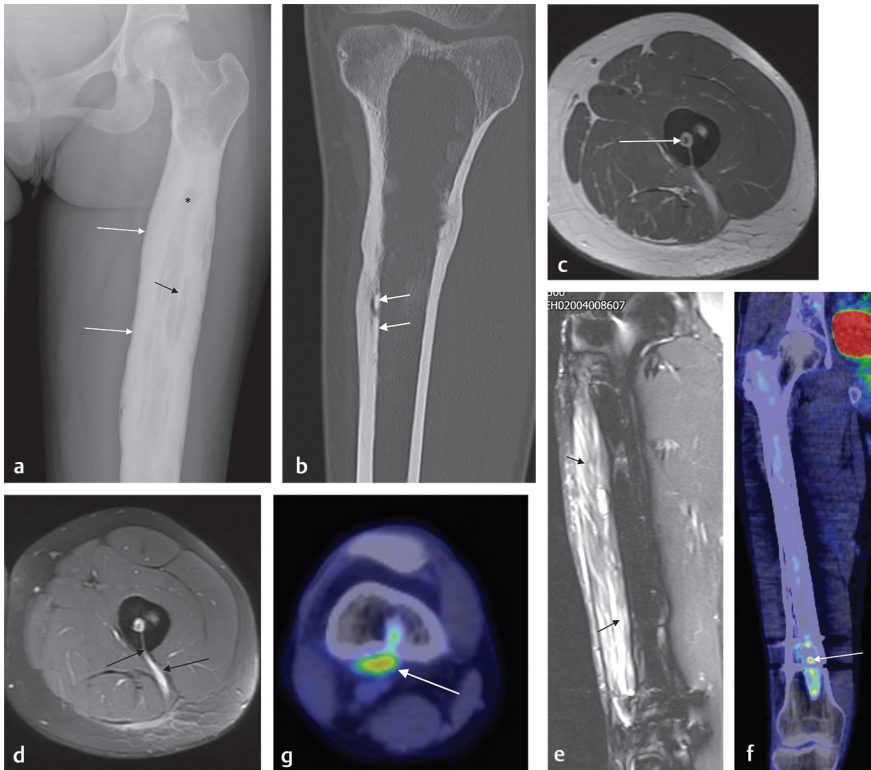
(a–e) Imaging modalities for osteomyelitis. (a) This plain X-ray shows features of chronic osteomyelitis with central sequestration (*black arrow*), bone lysis (*asterisk*), and mature involucrum formation (*white arrows*), causing thickening of the cortex. (b) Computed tomography (CT) of a tibia with extensive medullary osteomyelitis, previously treated with reaming. The residual endosteal sequestra (*white arrows*) are seen as radiodense areas under the thickened cortex. (c) Short-tau inversion recovery (STIR) and (d) T2 magnetic resonance imaging (MRI) images show central osteomyelitis with a sequestrum (*white arrow*), posterior cloaca, and sinus track (*black arrows*) to the subcutaneous tissue and a secondary area of bone lysis in the femur. Sinuses typically take the “route of least resistance” between muscles, along the intermuscular septum. (e–g) In this case of infection around an intramedullary nail, the MRI scan (e) shows the lateral soft-tissue inflammation well (*black arrows*) but cannot identify the area of bone involvement due to metal artefact. ^{18}F FDG PET-CT (f) coronal and (g) axial views show the medullary infection around the nail and demonstrate a cloaca passing posteriorly, forming a subperiosteal abscess (*white arrows*).
